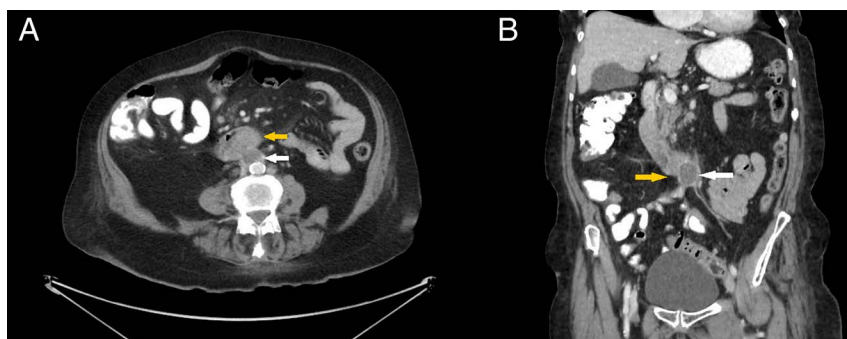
(A) Axial and (B) coronal abdominal and pelvic computed tomography showing a well-defined hypodense lesion with peripheral rim enhancement (white arrow) in the retroperitoneum, infiltrating third part of duodenum (yellow arrow) with adjacent asymmetric duodenal wall thickening.
